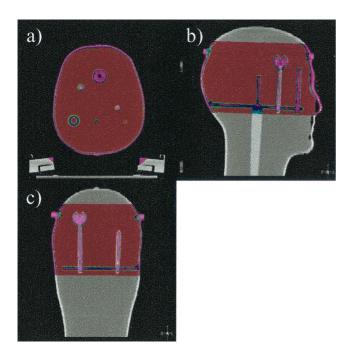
Grayscale primary CT scan with overlaid colorwash MRI scan. (a) Axial, (b) Sagittal, and (c) Coronal views.
